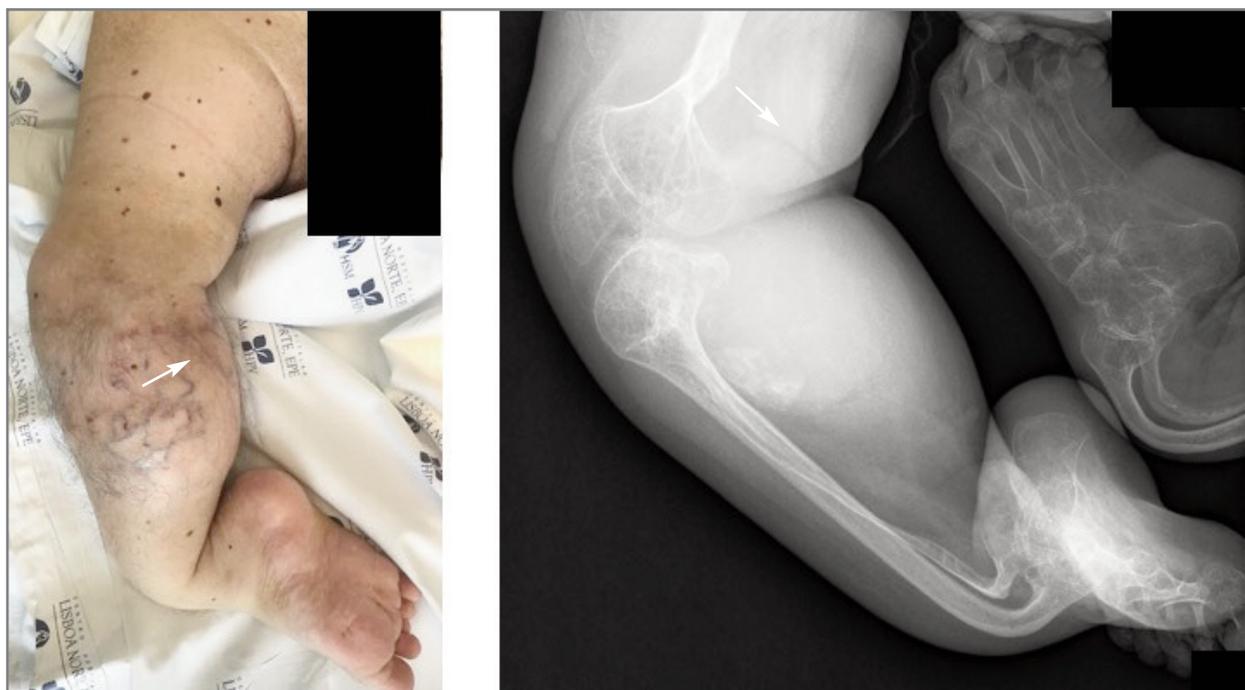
Left - Clinical photography showing a dysmorphic limb with increased volume and visible vascularization associated with a tumor/lesion in the right upper leg. Right - Plain X-ray showing severely dysmorphic bone structure and a neoformative process of the proximal right tibia.
